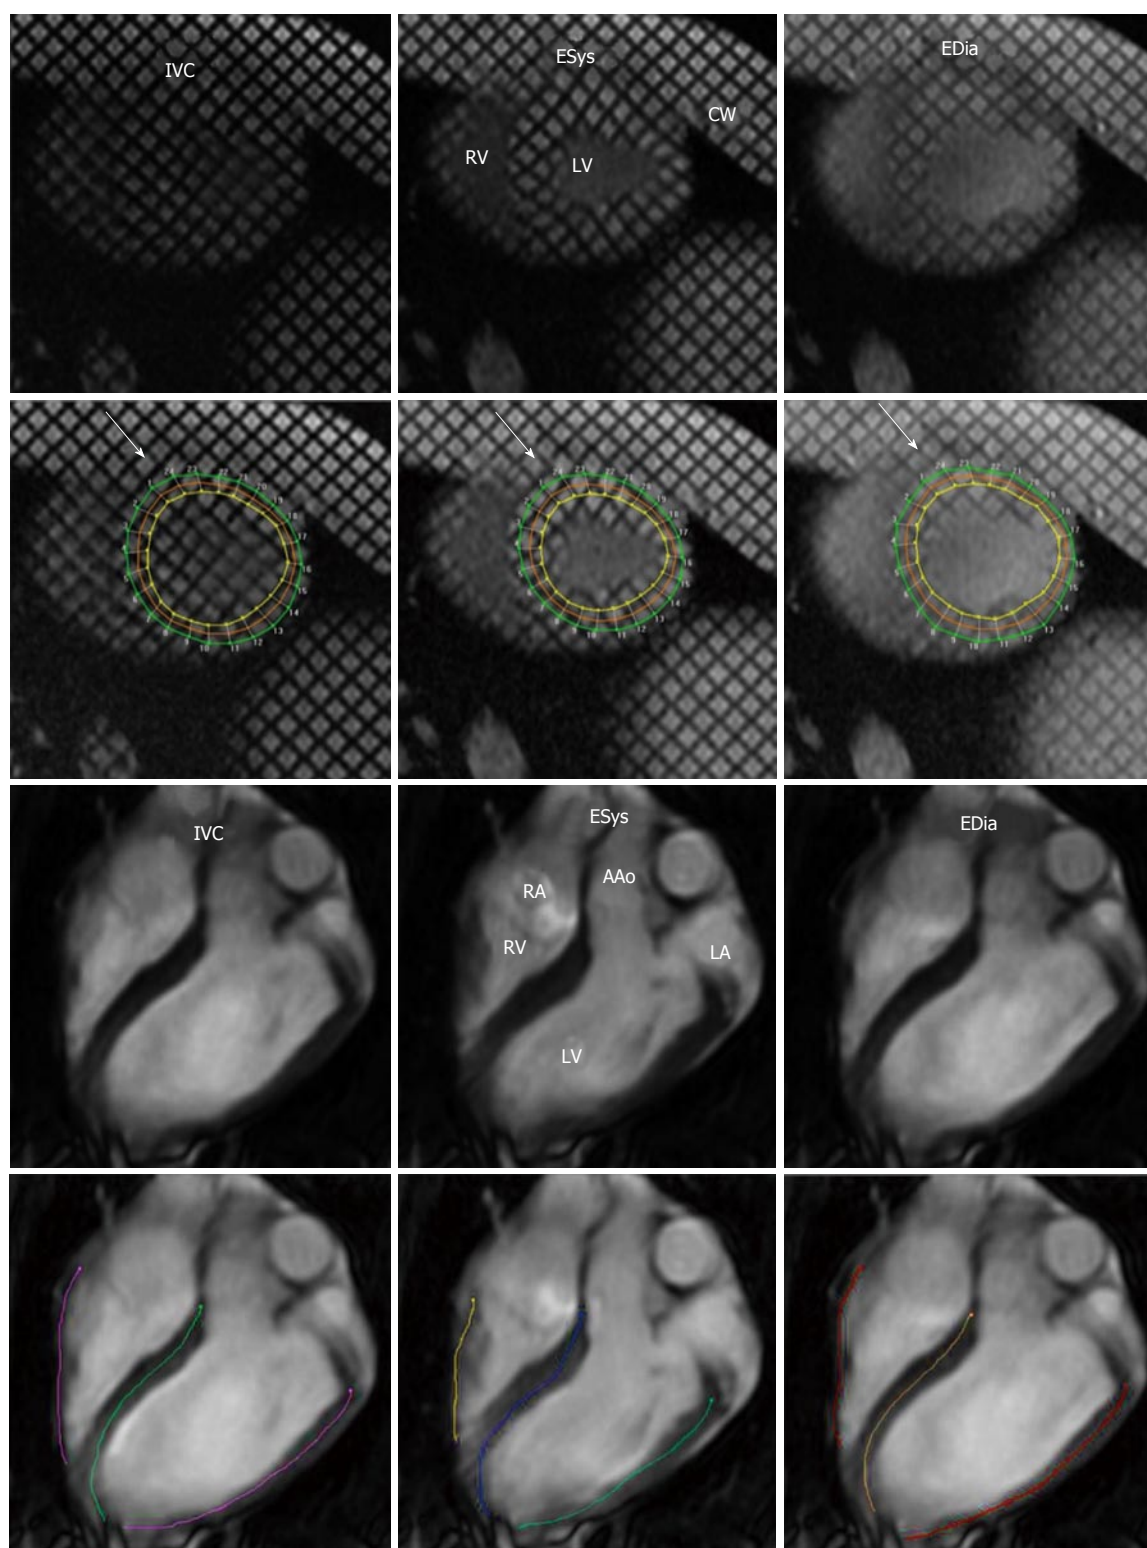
Representative tagged and cine magnetic resonance images with tracing method. Top row demonstrates short-axis and long-axis magnetic resonance images (MRI) images, while bottom row demonstrates images after tracing of the myocardium using HARP. Left three columns are cine tagged MRI and right three columns are cine MRI. IVC: Isovolumetric contraction; ESys: End systole; EDia: End diastole; LV: Left ventricle; RV: Right ventricle; CW: Chest wall; RA: Right atrium; LA: Left atrium; AAo: Ascending aorta.
